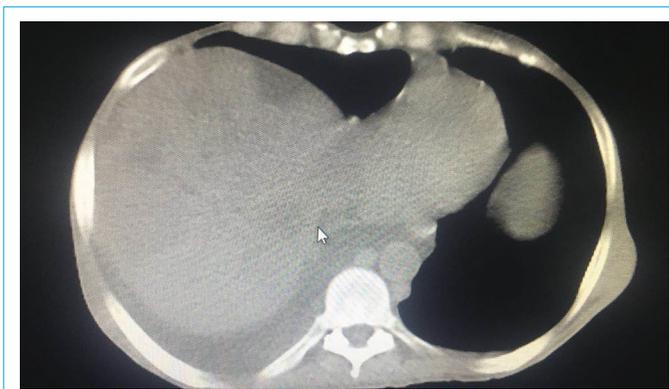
Computed tomography (CT) scan in 2016, the number of the lesions in the liver increased.
